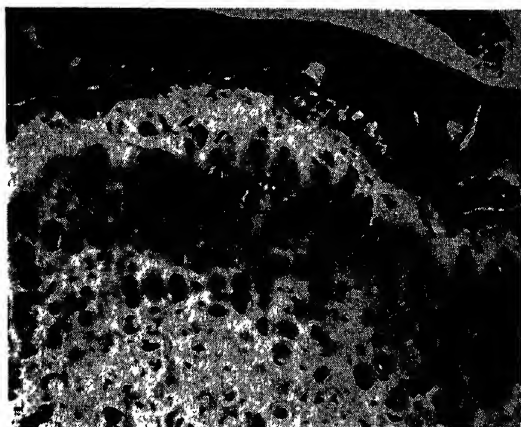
Epiphyseal plate 14 days after irradiation (1165 r). Although the columnar structure persists, the columns are irregular and component chondrocytes are swollen and in many instances pyknotic. Cartilage matrix is mottled in appearance.  $\times 150$ . (J. S. Barr, J. R. Lingley, and E. A. Gall: *Am. J. Roentgenol.*)
